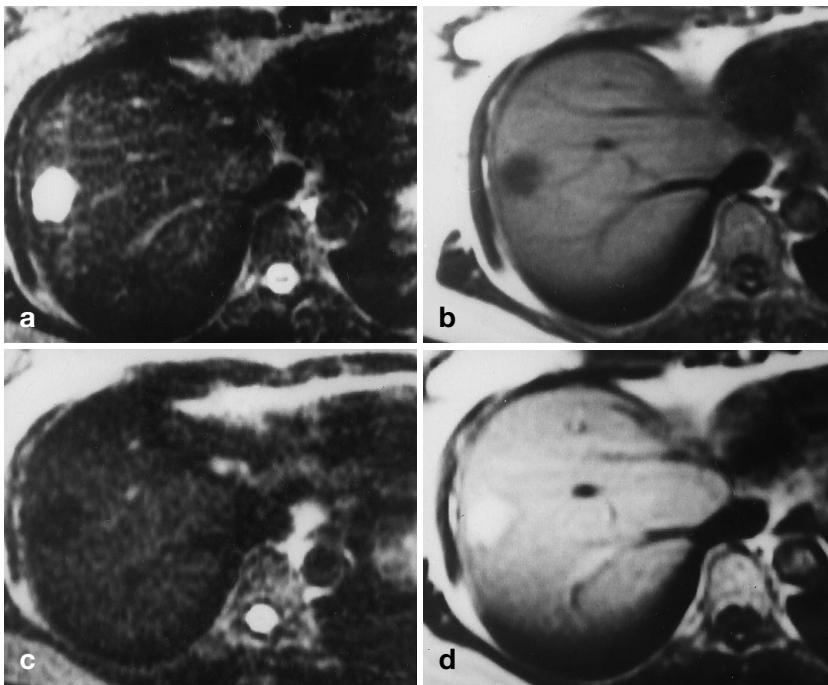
a–d. Enhancement of benign lesions: hemangioma. T1- and T2-weighted SE images of a hemangioma in the right liver lobe before and after infusion of AMI-227 (1.7 mg Fe/kg). On T2-weighted images (a, b pre-contrast; c, d post-contrast) signal is reduced in liver, hemangioma and intrahepatic vessels after AMI-227. In comparison, on T1-weighted images there is uniform enhancement of the hemangioma. (Images courtesy of Sanjay Saini, M. D.)
